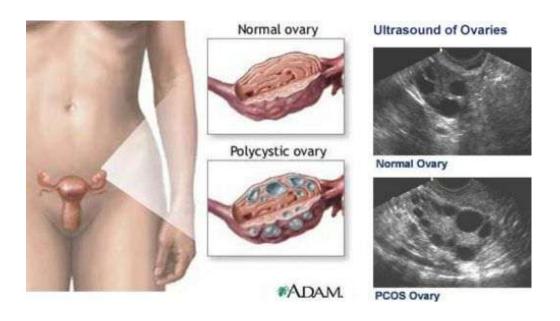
polycystic ovarian syndrome – (<u>www.ultrasoundimagegallery.com</u>)
